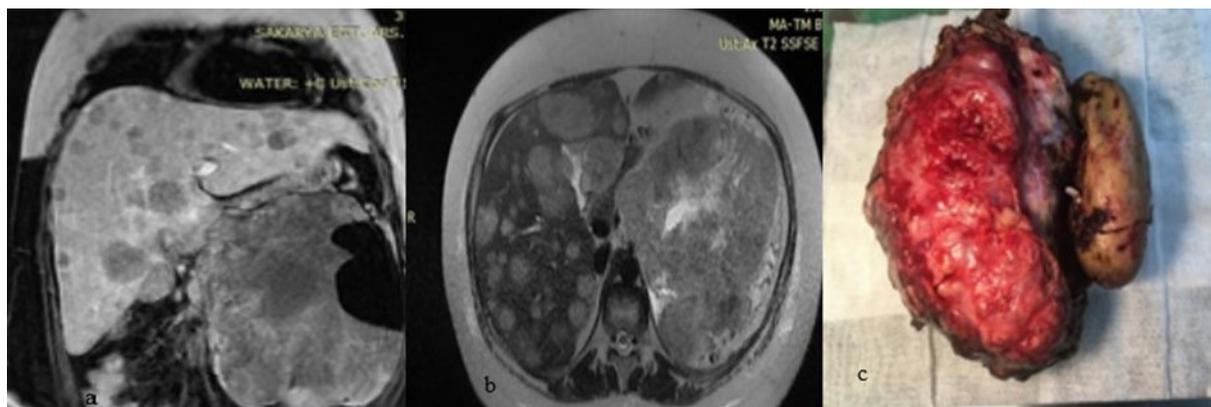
2a and 2b: MRI imaging revealed the mass and metastasis to the liver in second case; 2c: the postoperative appearance of the mass with a diameter of 15 cm including the renal pelvis and ureter.
